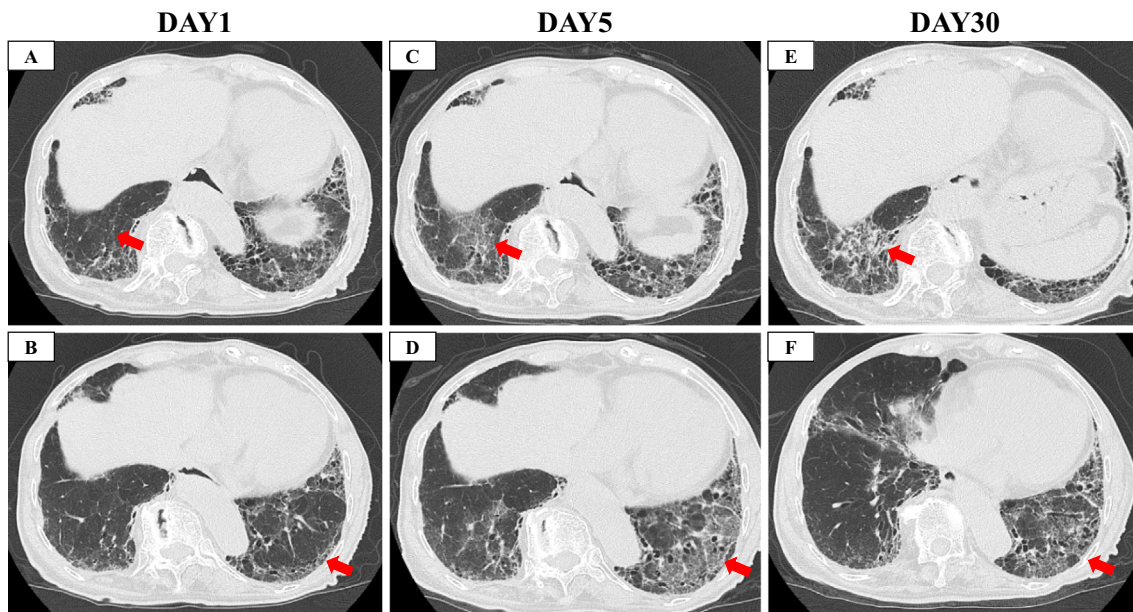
Computed tomography images. A, B: On the day of admission to our hospital. C, D: On the day of the initiation of steroid therapy (five days after admission). E, F: Two weeks after the initiation of steroids. Red arrows show newly observed ground-glass opacity (GGO), and red arrow heads show honeycomb.
